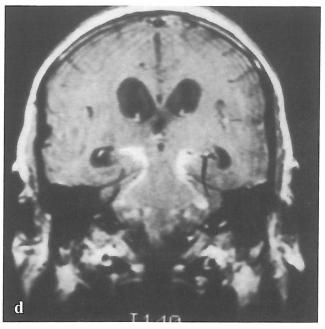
(a-b): Fungal meningoencephalitis in AIDS; Axial post-contrast T1 weighted MR images in (a) cryptococcal and (b) coccidioidomycotic meningo-encephalitis demonstrate focal cortical enhancement with associated lepto-meningitis in the sylvian sulcus and in basal cistern.
